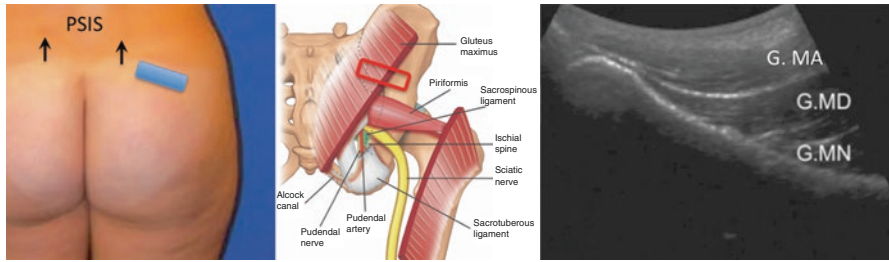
Position of the ultrasound probe over the iliac crest and the pertinent anatomy and sonoanatomy. PSIS, posterior superior iliac spine; arrow, dimple of Venus approximating the position of PSIS; G. MA, gluteus maximus; G. MD, gluteus medius; G. MN, gluteus minimus. (Reprinted with permission from Philip Peng Educational Series)
